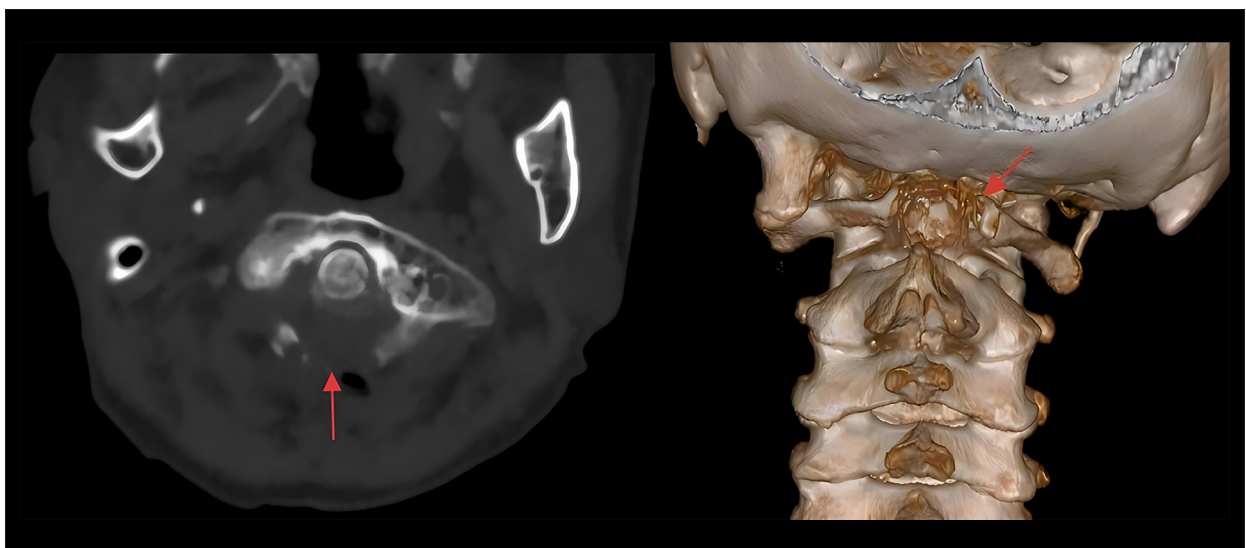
Postoperative computed tomography scan (2024) showing resection of the posterior arch of the atlas.
